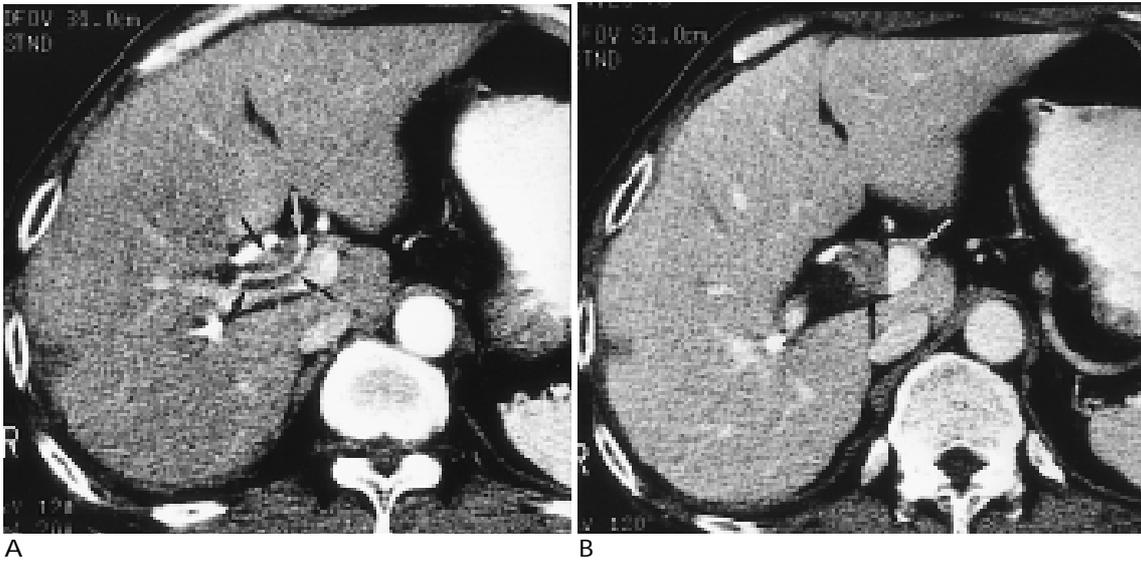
Hepatic arterial invasion without luminal change, correctly diagnosed on the basis of CT findings.
